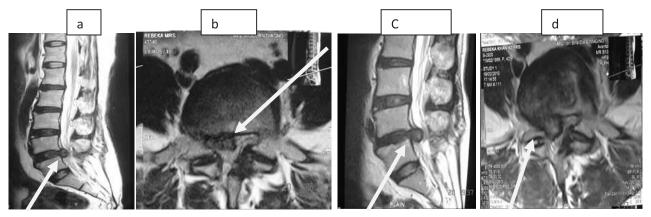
(a, b) Sagittal and corresponding axial T2-weighted magnetic resonance image (MRI) shows lumbar disc herniation at L4-5 level (right), limited discectomy was done on 15.1. 2004 and (c, d) same patient showed recurrent disc prolapse after 1.5 years at same level and same side which is shown at sagittal and corresponding axial T2-weighted MRI (arrow mark).
